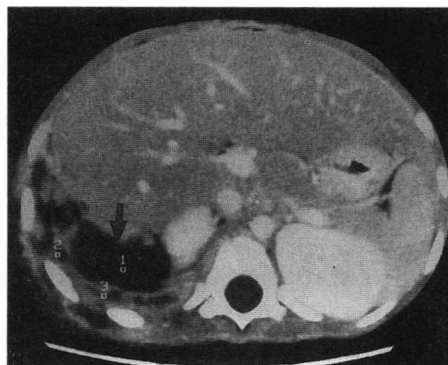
CT scan of the upper abdomen/chest showing an infiltrating *Basidiobolus ranarum* lesion extending into the abdominal and thoracic wall.
